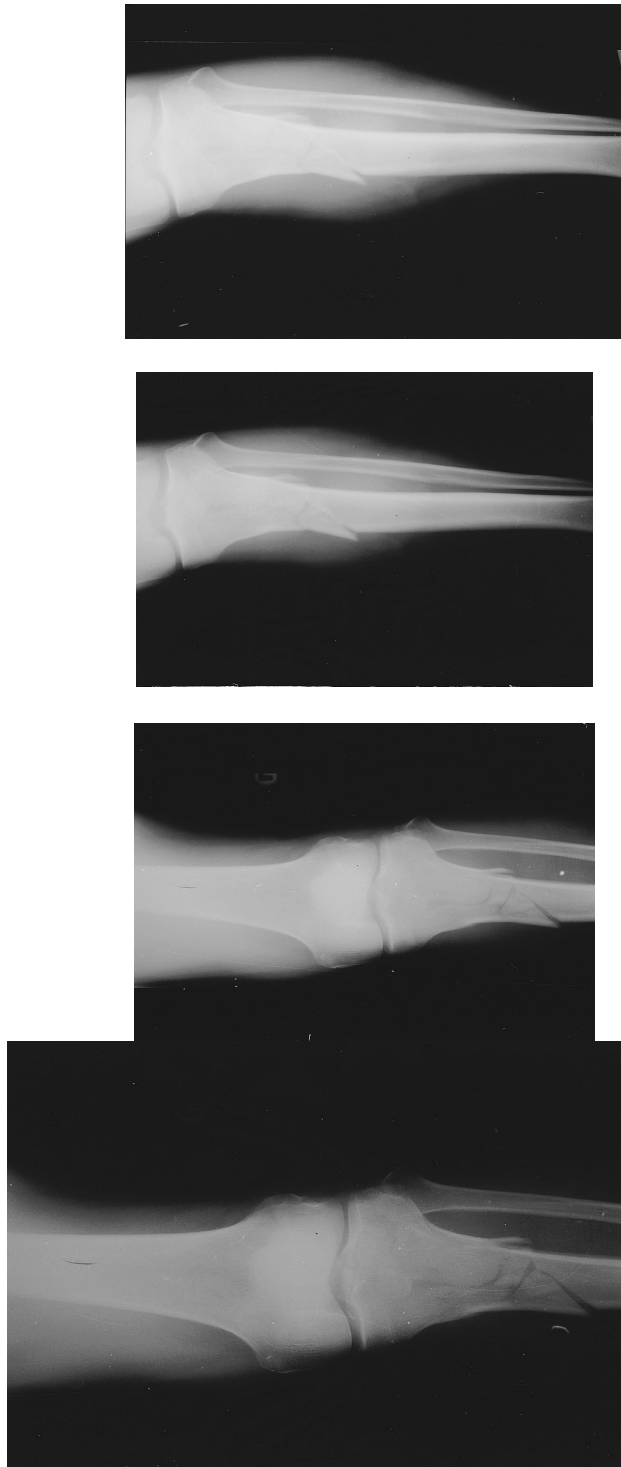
Radiographs from PWC File 10.
